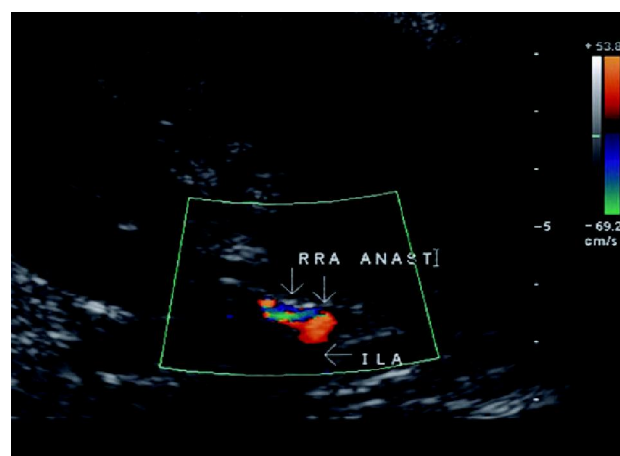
Renal artery stenosis. Color doppler image of the transplant renal artery near anastomosis with the iliac artery (ILA) shows aliasing and heterogeneous signal compatible with the turbulent, high-velocity blood flow at the site of stenosis.
